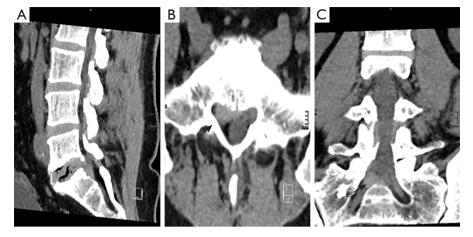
Sagittal (A), axial (B) and coronary (C) CT examination upon first admission showing a hyperdense intraspinal mass compromising the S1 root on the right (arrows).
